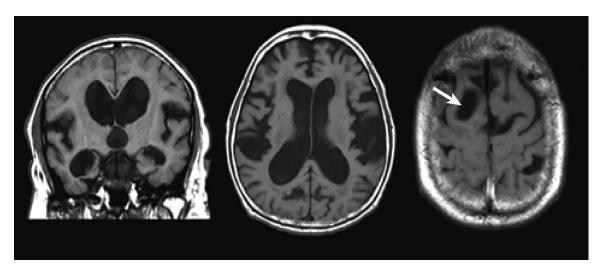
DESH. Typical MRI of a patient with iNPH. Narrowing of the CSF spaces near the vertex and widening of the Sylvian fissure are good indicators that iNPH will respond to treatment. The few wide sulci that are seen on the cerebral convexity (white arrow) are all in the vicinity of large, superficial arteries. DESH: disproportionately enlarged subarachnoidspace hydrocephalus, MRI: magnetic resonance imaging, CSF: cerebrospinal fluid, iNPH: idiopathic normal pressure hydrocephalus.
